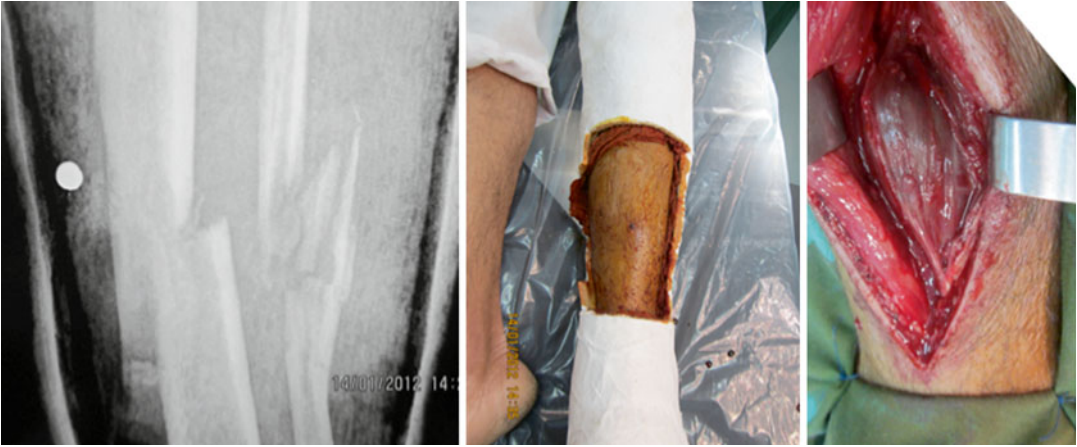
From left to right, the causal pellet on the X-ray film, the clinical picture and the false aneurysm dissected. After proximal and distal ligation of the anterior tibial artery, the parietal haematoma was simply removed
